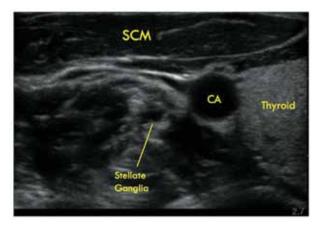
Ultrasound image of stellate ganglia and other relevant anatomy: sternocleidomastoid muscle (SCM), carotid artery (CA) and thyroid tissue.
